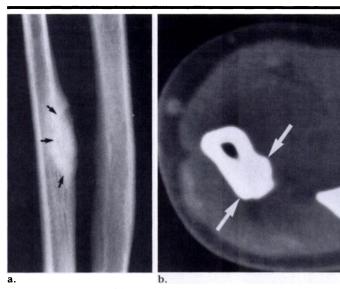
Osteoma of long bone. (a) Posteroanterior radiograph of the midforearm shows a dense lesion (arrows) involving the cortex of the ulna. (b) Axial CT image. The lesion (arrows) is of uniform attenuation. The medullary cavity is not involved.
